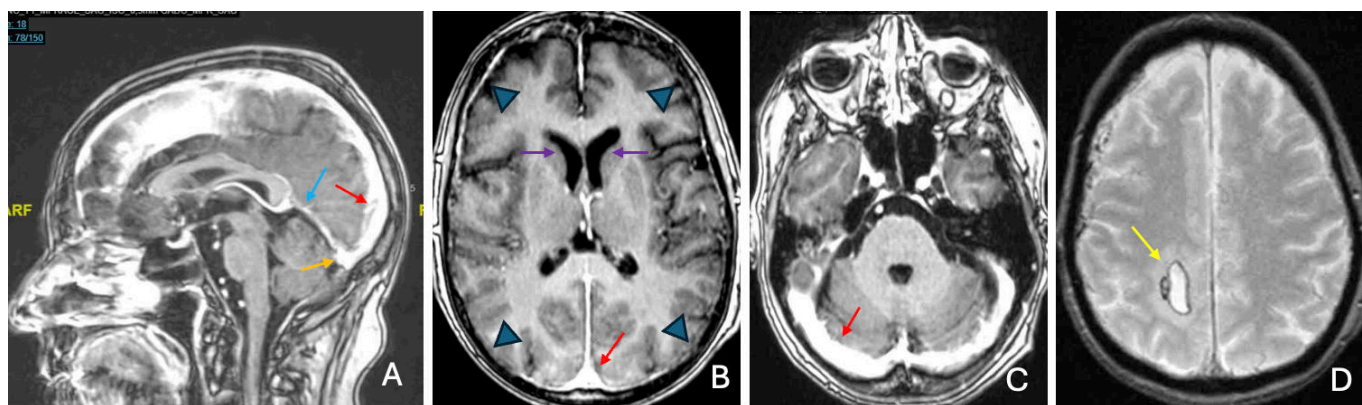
(A) Sagittal gadolinium-enhanced brain T1-weighted MRI 5 days after cerebrospinal fluid-venous fistula embolization, demonstrating resolution of superior sagittal (red arrow) and torcular (orange arrow) sinus thrombosis, as well as resolution of straight sinus engorgement (blue arrow). (B) Axial gadolinium-enhanced brain T1-weighted MRI showing resolution of bilateral pachymeningeal enhancement (arrowheads), recanalization of the superior sagittal sinus (red arrow), and increased lateral ventricle diameter (purple arrows). (C) Patent right transverse venous sinus (red arrow). (D) Stability of the hemorrhagic transformation of the frontal parenchymal infarction.
